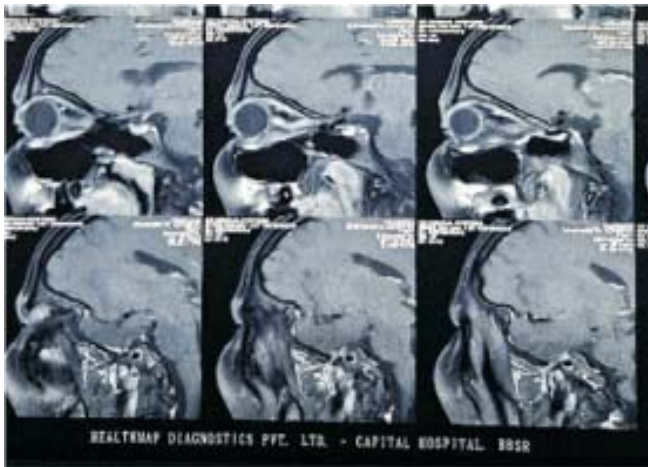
MRI-Orbit showed T2 hyperintensity with differential enhancing seen in intra-orbital part of left optic-nerve suggestive of Optic-Neuritis.
